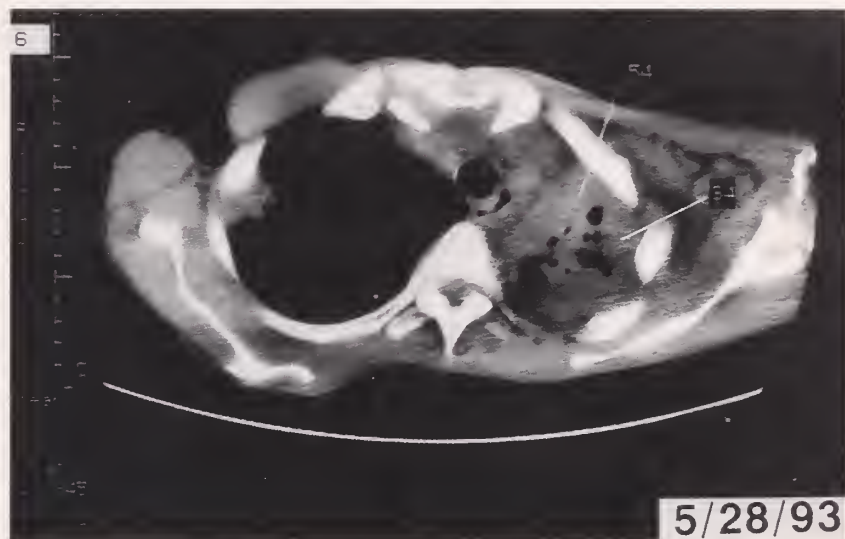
Thoracic Actinomycosis Left Apical Cavitary Lesion on CT scan.
